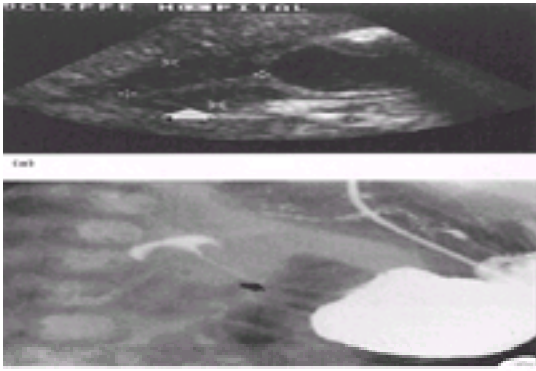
(a) Ultrasound demonstrating the hypertrophied muscle (white arrow) of hypertrophic pyloric stenosis. (b) Barium meal demonstration of the elongated narrowed pyloric canal (black arrow) of hypertrophic pyloric stenosis.
